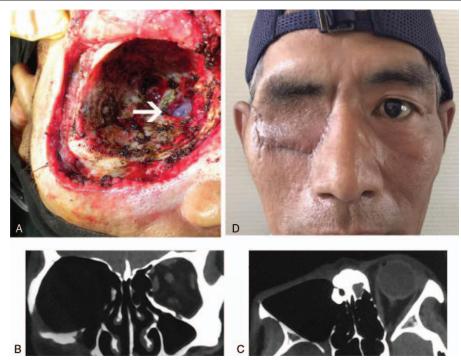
Surgical image. Postoperative CT images and postoperative photo of patient. A. The complete orbital content was enucleated and a canal between the orbital cave and enthmoid sinus was established (white arrow); B, C. Postoperative CT view shows that an empty orbital cavity without effusion is covered with a myocutaneous flap; D. Postoperative photo of patient at 3-week follow-up. CT=computed tomography.
